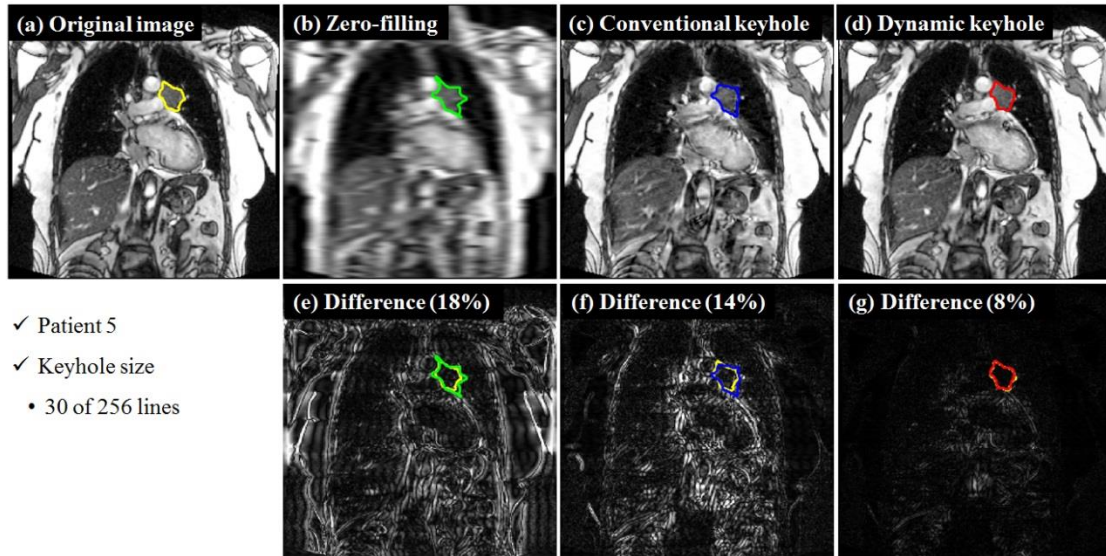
Reconstructed MR images of (a) original full k-space image, as well as reconstructed MR images with a constant keyhole size of 30 of 256 phase encoding lines for (b) zero-filling, (c) conventional keyhole and (d) dynamic keyhole. (e), (f) and (g) display the difference (and percentage of difference) between original image and the reconstructed zero-filling, conventional keyhole, and dynamic keyhole images, respectively. Lung tumors were contoured on the reconstructed images in different colors: (a) original image (yellow), zero-filling (green), conventional keyhole (blue) and dynamic keyhole (red) methods.
